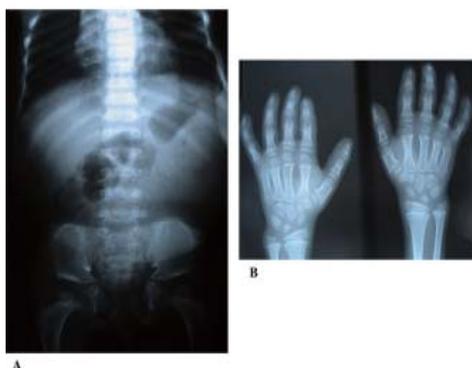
X-ray (PA view) of thoracolumbar vertebrae, chest and pelvis in case 8 with DMC syndrome at 10 years of age showing flat vertebrae, thin ribs and lace like appearance of iliac bones (A). X-ray of both hands (PA view) showing short metacarpals and phalanges with broad metacarpal ends (B)
